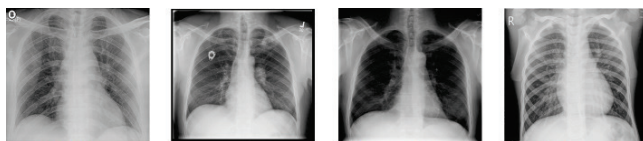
Chest x-rays of COVID-19, Lung Opacifications, Healthy (Normal) and Viral Pneumonia
